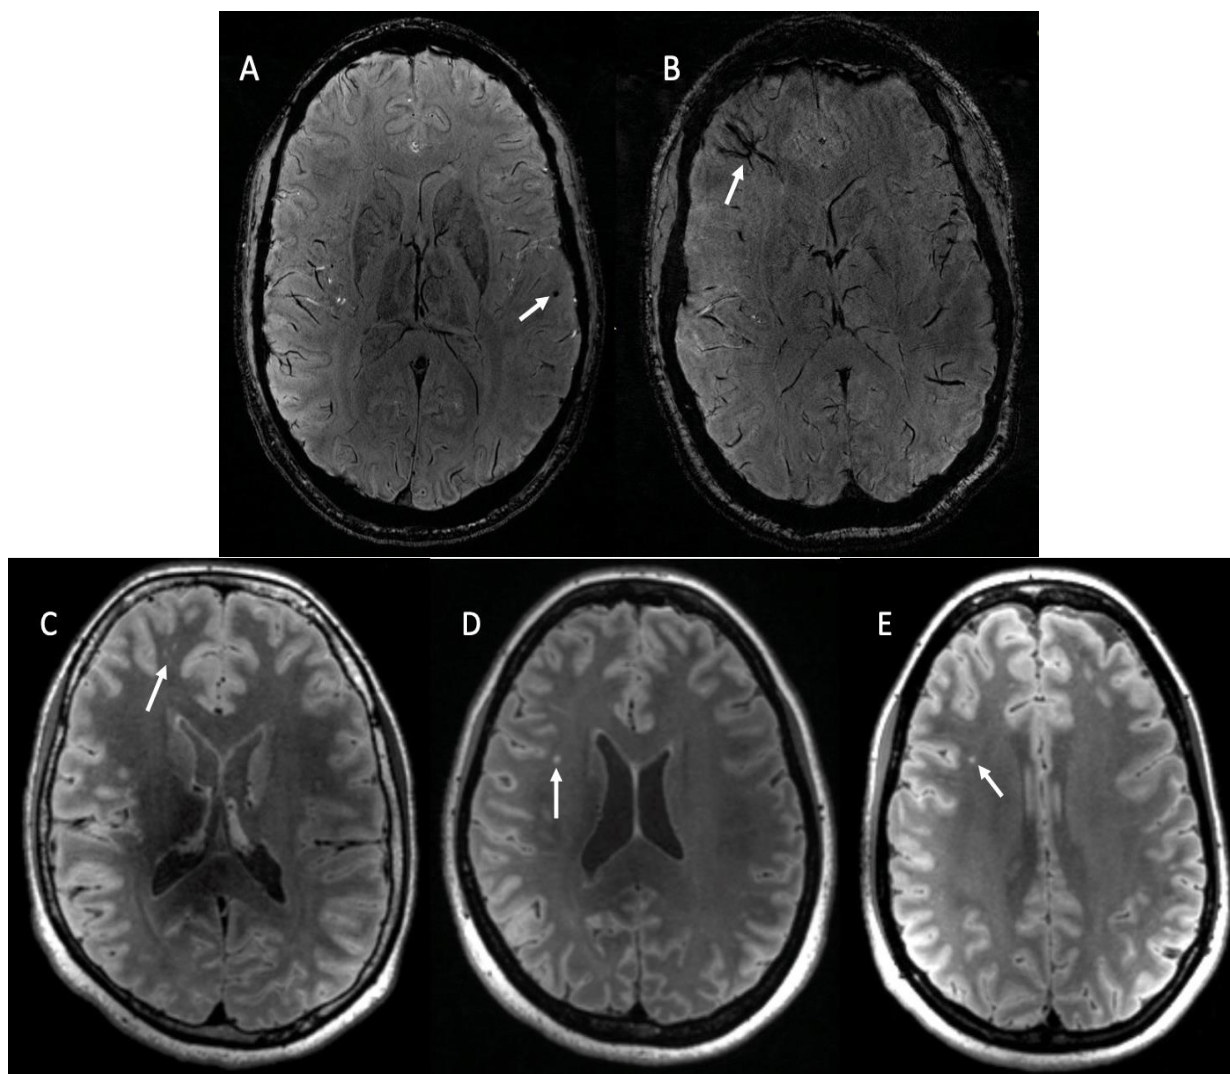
Examples of WM hyperintensity and abnormal susceptibility. A: Axial GRE (slice thickness 1.25mm) of a 35-39 year old man with a punctate focus abnormal susceptibility on the left superior temporal gyrus; B: Axial GRE (slice thickness 1.25mm) of a 35-39 year old woman with a developmental venous anomaly in the right anterior frontal lobe; C: Axial FLAIR image (slice thickness 0.8mm) of an 18-24 year old woman D: Axial FLAIR image (slice thickness 0.8mm) of a 35-39 year old woman; E: Axial FLAIR image (slice thickness 0.8mm) of a 30-34 year old woman. All three FLAIR images show nonspecific foci of hyperintensities in the bilateral cerebral WM with frontal lobe predominance commonly seen in patients with migraines. Age ranges are provided to maintain anonymity.
